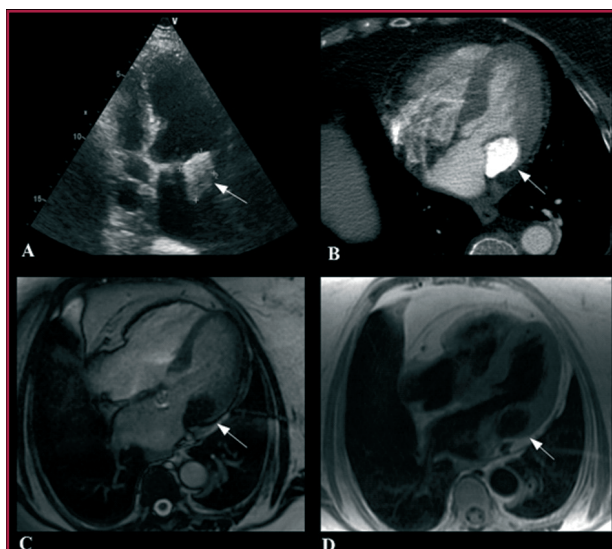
A. Transesophageal echocardiography showing high echogenic thickening in all the posterior area of the mitral valve annulus, consistent with severe annular calcification. B. Computed tomography scan (Figure 1 B) showing a calcified nodular lesion with a less dense thin peripheral annulus, and calcification of the posterior margin of the mitral valve, suggestive of caseoma. C and D. Magnetic resonance in steady-state-free-precession (SSFP) and double inversion recovery (IR) T1-weighted sequences showing a hypointense nodular image with well-defined contours in the mitral valve annulus, consistent with caseoma.
